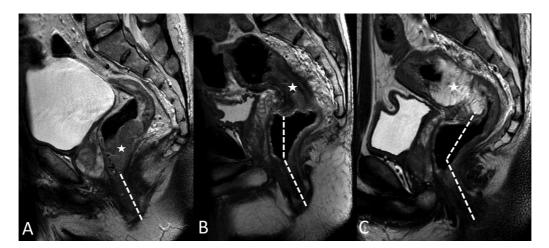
Sagittal T2 high-resolution (HR) magnetic resonance imaging (MRI) in three different patients demonstrating signal intensity, location (dashed line from the anal verge), and morphology of rectal cancer (*) on baseline MRI. (A) Posterior semiannular intermediate signal intensity low rectal cancer (distal margin below 5 cm from the anal verge). (B) Annular T2 hypointense mid-rectal cancer (between 5 and 10 cm from the anal verge). (C) Annular hyperintense high rectal cancer (above 10 cm from the anal verge or above the peritoneal reflection).
